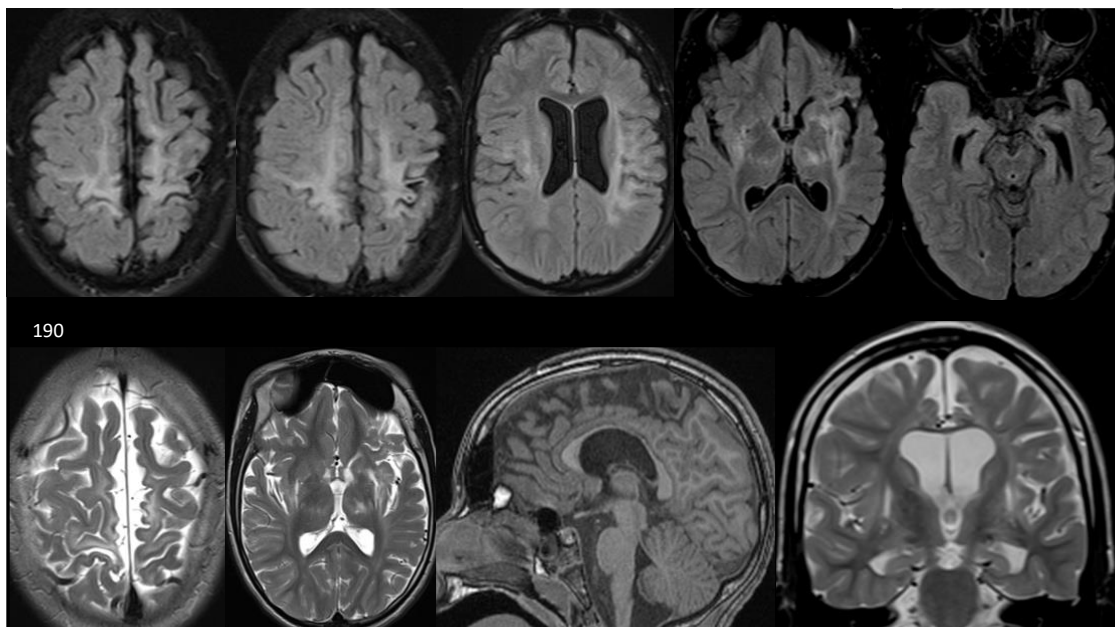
Collage of MRI images obtained for patient 190
